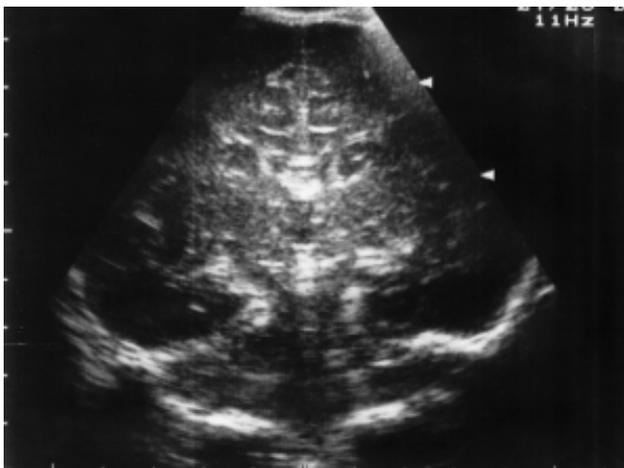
Sagittal and coronal view of ultrasound brain of our patient.
